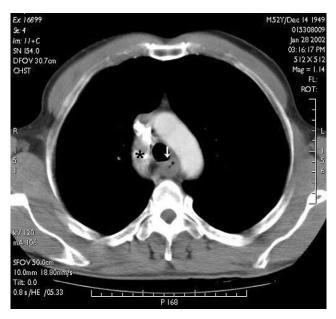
Chest CT image proves a down-staged mid-esophageal mass after neoadjuvant chemoradiotherapy (arrow). The tumor and lymphadenomegalies are unappreciable. Dilated azygos vein and arch (asterisk) along with an absent intrathoracic inferior vena cava reconfirm azygos-caval anomaly.
